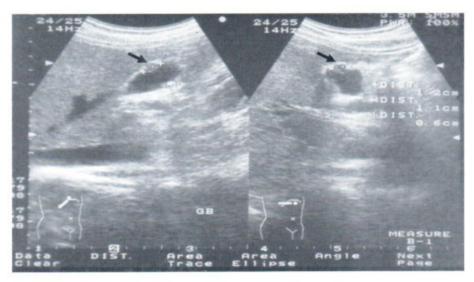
Chronic cholecystitis with mucus cyst. Ultrasound demonstrates contracted gallbladder with a hypoechoic nodule at anterior wall (arrows).
